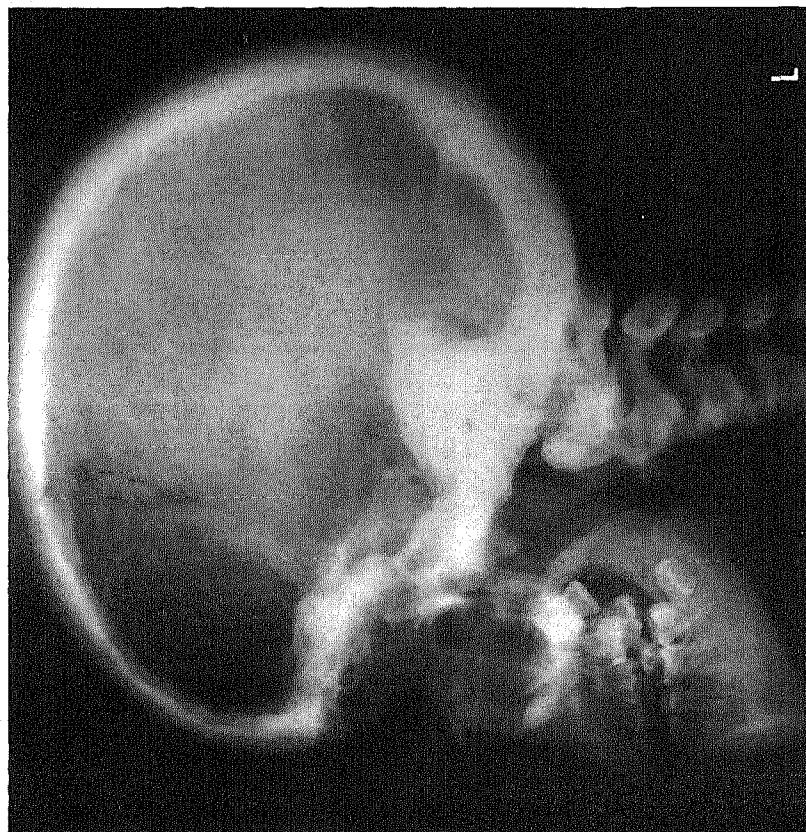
(left). Skull, lateral radiograph. The striking increase in thickness and density of most bones is greatest in the base of the neurocranium, especially in the petrous portions of the temporal bones. The calvaria shows slight involvement; the hyperostosis and sclerosis of the inner and outer tables appear to have obliterated the diploë. The sella turcica is enlarged and the inner cortex is lost along the floor and the dorsum. No mastoid air cells are visible, yet the paranasal sinuses are well pneumatized. The body of the mandible is greatly thickened.
